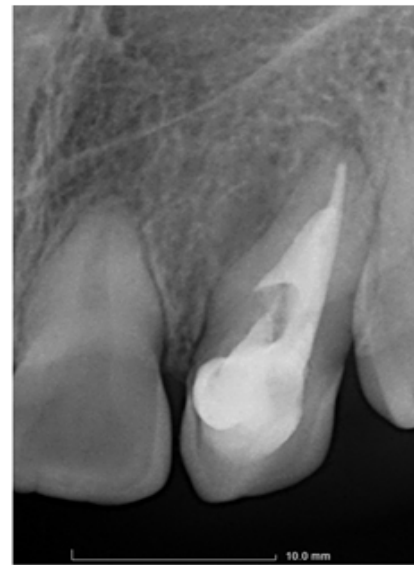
Periapical radiography after three months showing reduction of periapical lesion
